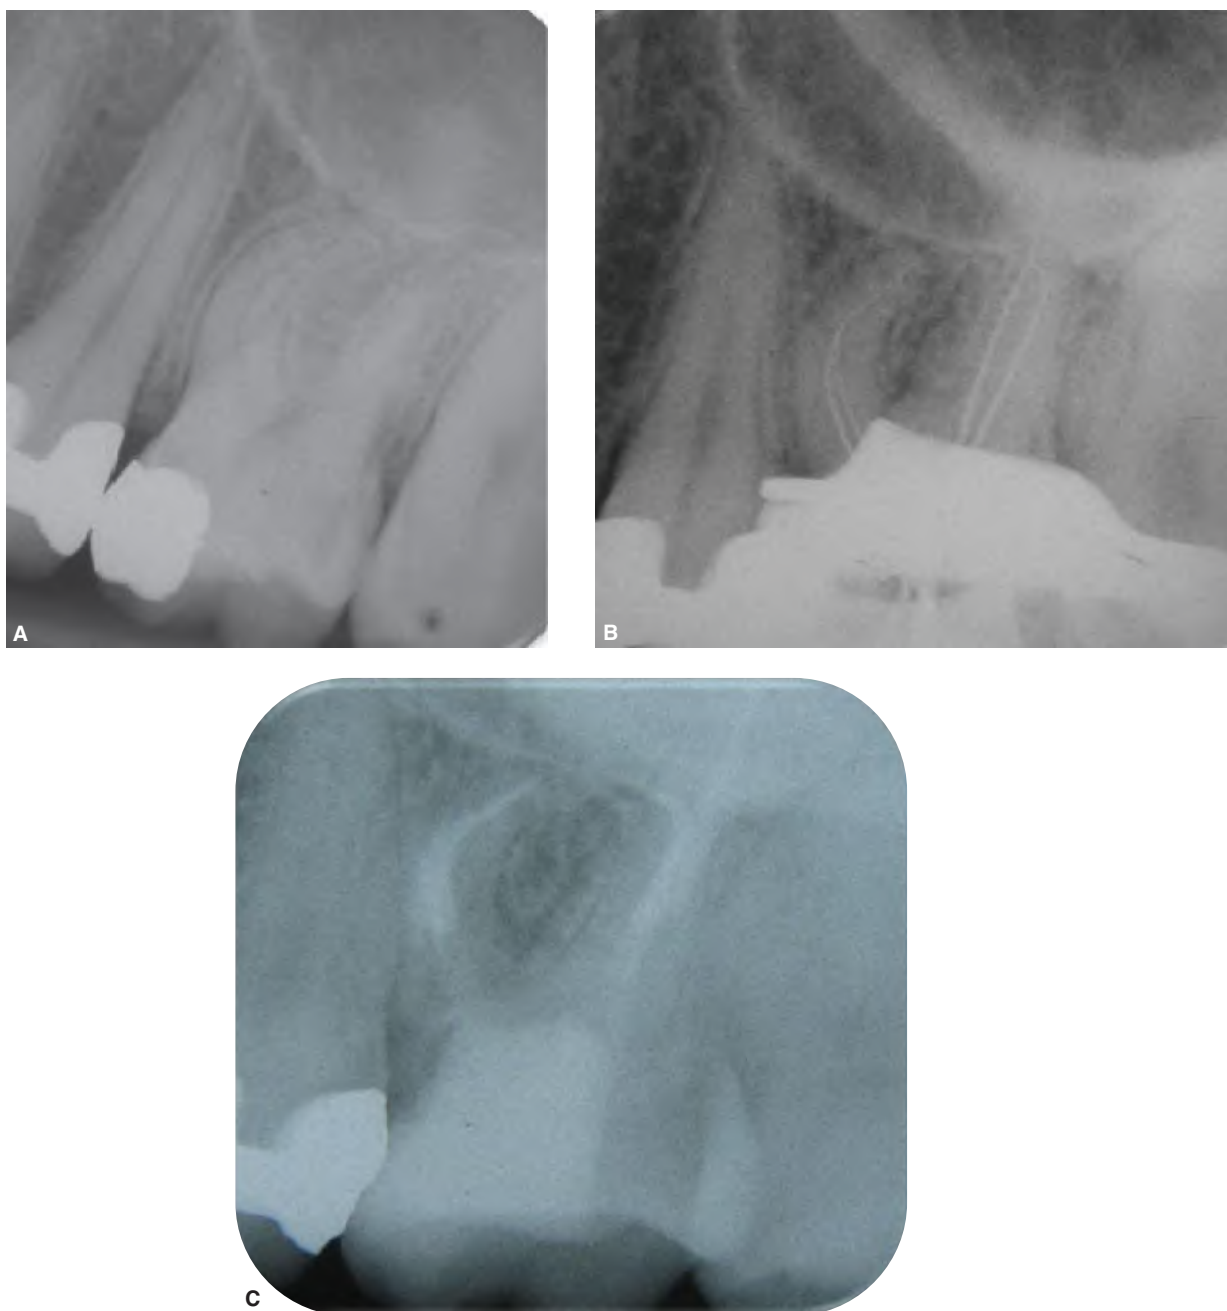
A-C. Preparation of these severely curved root canals demonstrates a good flow of the preparation following the original axis of the four root canals without radiographically visible deviation, straightening, or apical transportation. Note complete severity of the curves becomes evident only when the length determination radiograph is taken.
